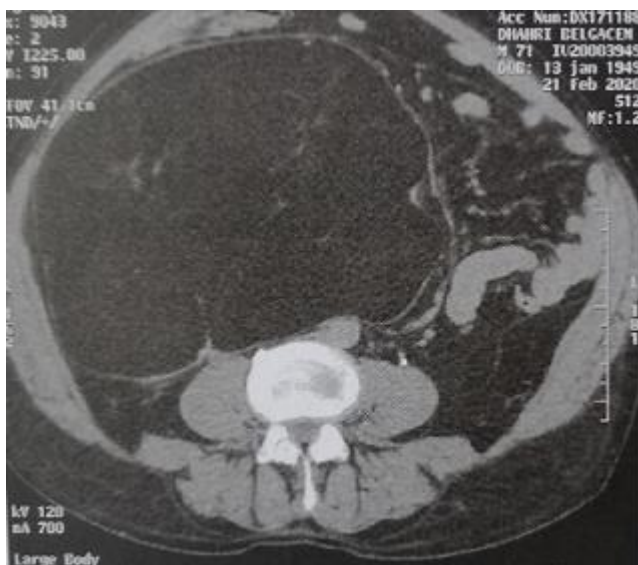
abdominal computed tomography showing a large retro-peritoneal lipomatous mass of 22 × 20 cm containing multiple septa.
